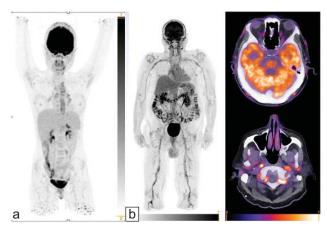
(A) 18FDG PET/CT (MIP image) in 16 year old girl showing enhanced tracer uptake over thoracic and proximal abdominal aorta [Grade III -higher than liver]. (B) 18FDG PET/CT in 80 year old male with LV-GCA (MIP image) and C-GCA (fused axial slices).
